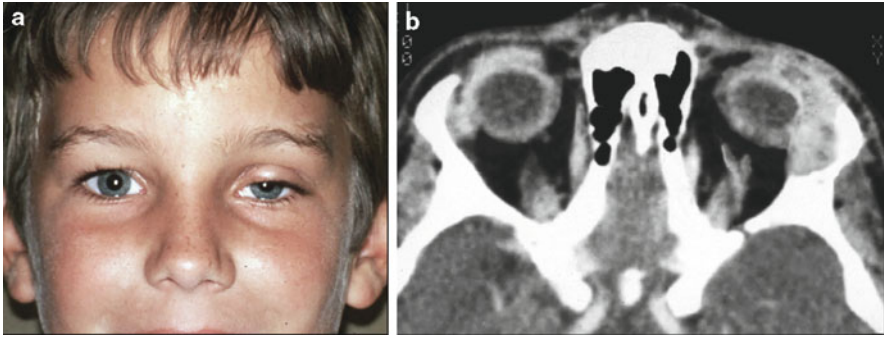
(a) Eosinophilic granuloma at the left superotemporal orbital rim, causing ptosis of the upper eyelid. (b) CT scan showing the lesion originating in the zygomatic bone
